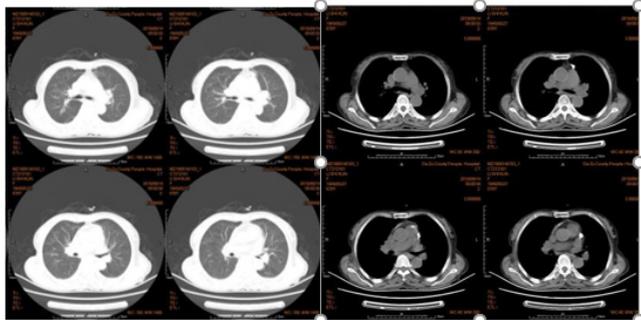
Chest computed tomography scans show an increase in bronchial vascular bundles in both lungs, disorganized alignment, and a diffuse flocculent and cloudy fuzzy shadow in both lungs, which was significantly absorbed compared to previous scans.
